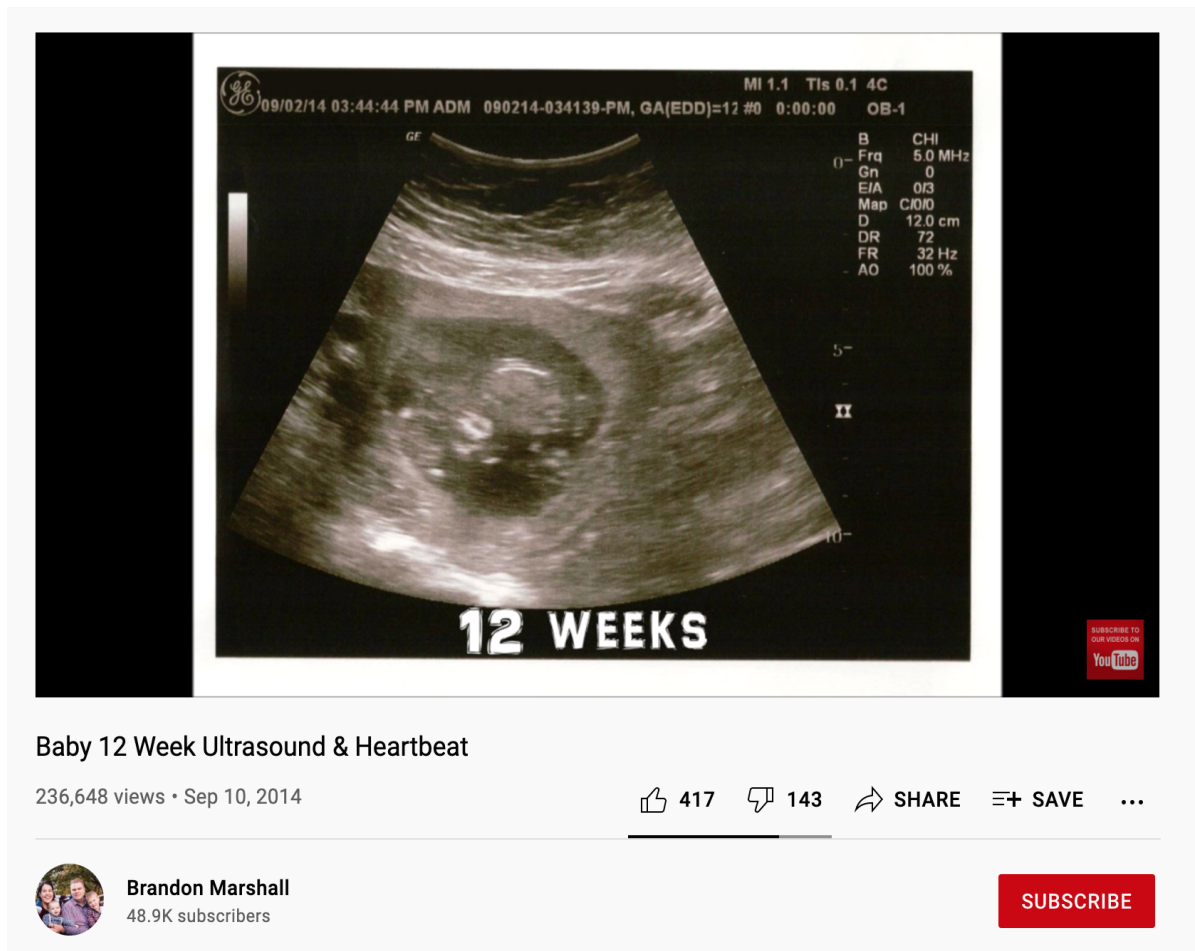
Brandon Marshall*, “Baby 12 Week Ultrasound & Heartbeat” YouTube, September, 10 2014.
